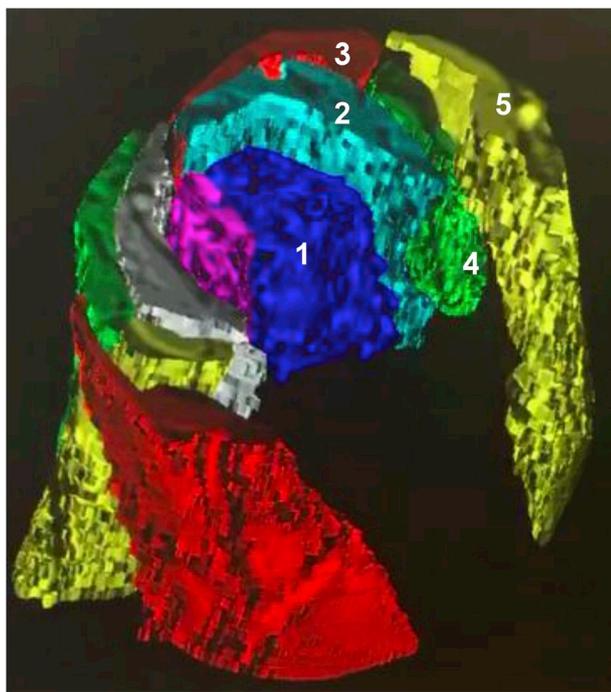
Three-dimensional model created in Analyze 12.0 and used by raters to check their identification of the lower cervical extensor muscles (1 = multifidus with semispinalis cervicis; 2 = semispinalis capitis; 3 = splenius capitis with splenius cervicis; 4 = levator scapulae; 5 = sternocleidomastoid) as quantified by MRI at spinal levels C3–C6.
